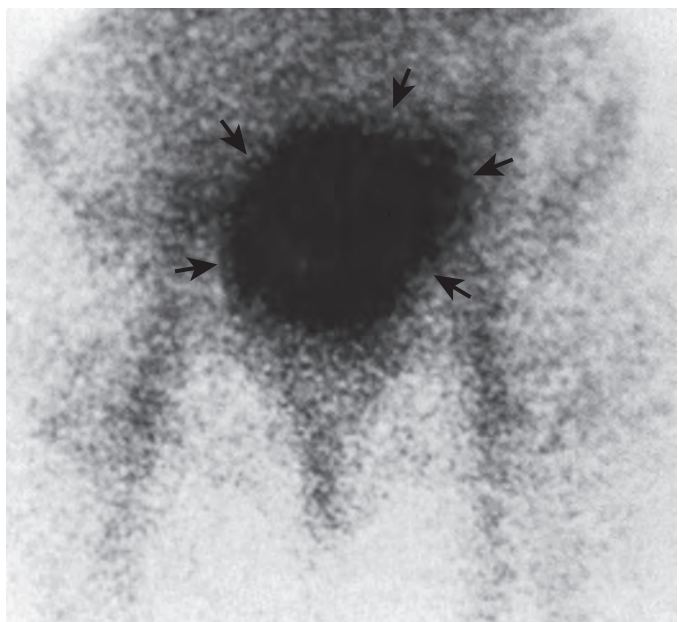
Immunoscintigraphy of recurrent rectal carcinoma. A large mass of high uptake (arrows) is seen in the pelvis of a patient with recurrent rectal tumor.
